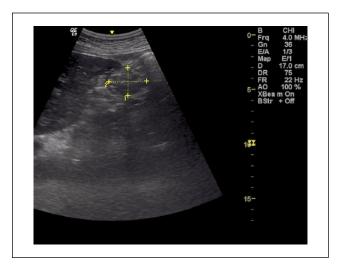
Gastric antrum ultrasound appearance of aspirated tube feed volume of 10 mL (aorta as landmark). 1, 2.5 cm; 2, 3.4 cm.
